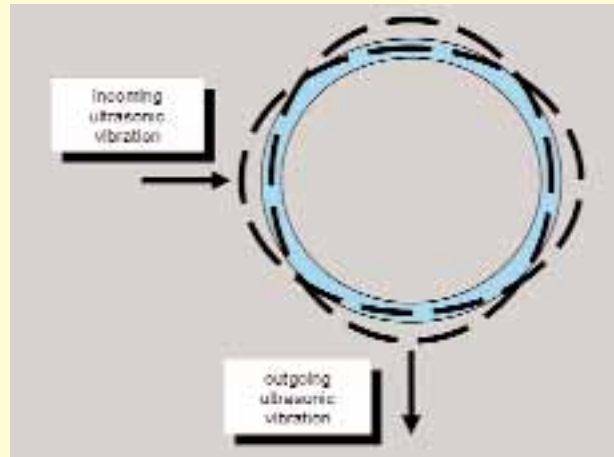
90° deflection of the horizontal ultrasonic vibration by the resonating ring
